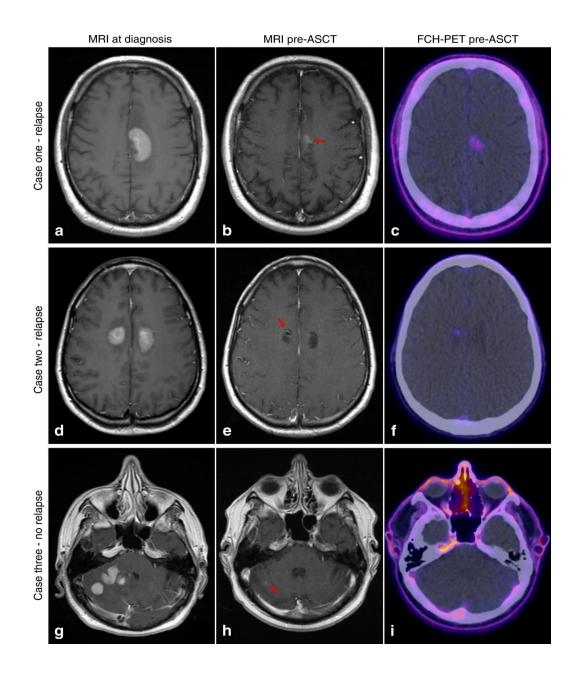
Original data from three cases. FCH PET-CT and CE-MRI findings pre-autologous stem cell transplantation (ASCT), prognostic value for patient clinical outcomes post-ASCT.
